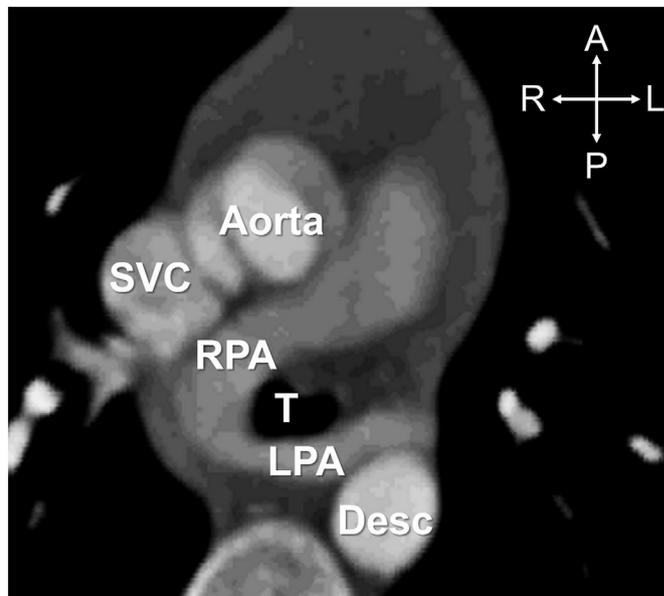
Computed tomography axial image. The left pulmonary artery (LPA) arises in anomalous fashion from the right pulmonary artery (RPA) and is located behind the trachea (T) causing its compression. SVC – superior vena cava, Desc – descending aorta. Philips Brilliance CT, 40 slice, 140 kV.
